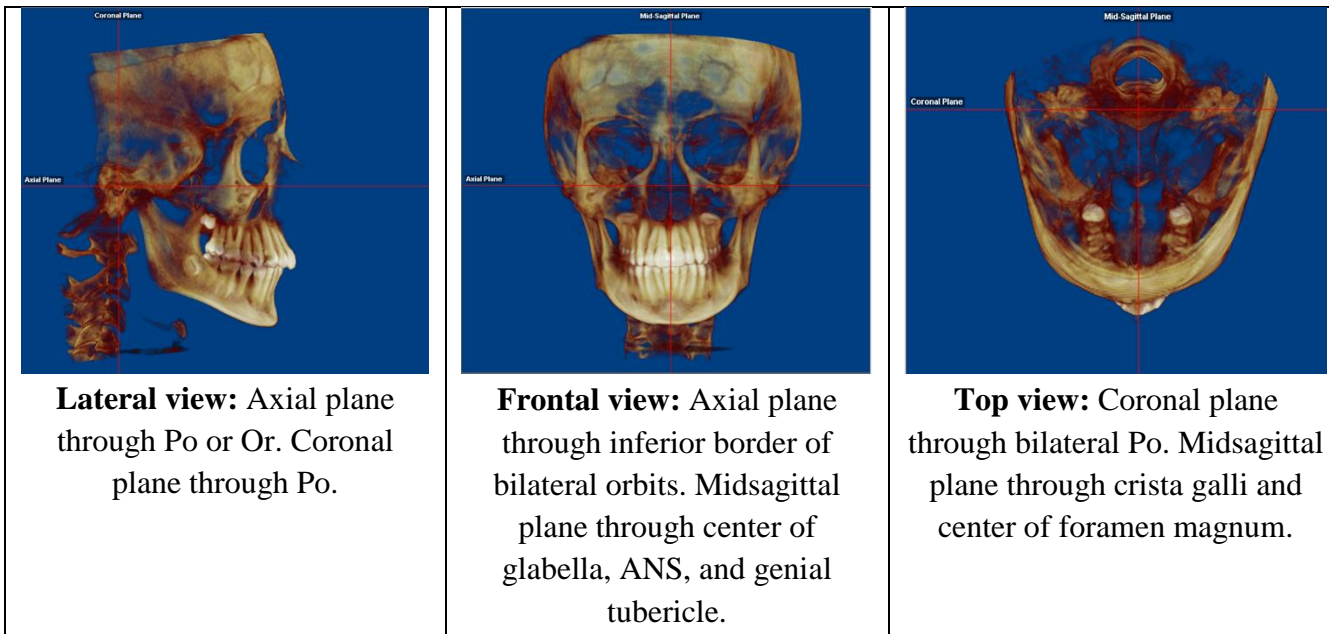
Oriented CBCT scans for lateral, frontal, and top views.
